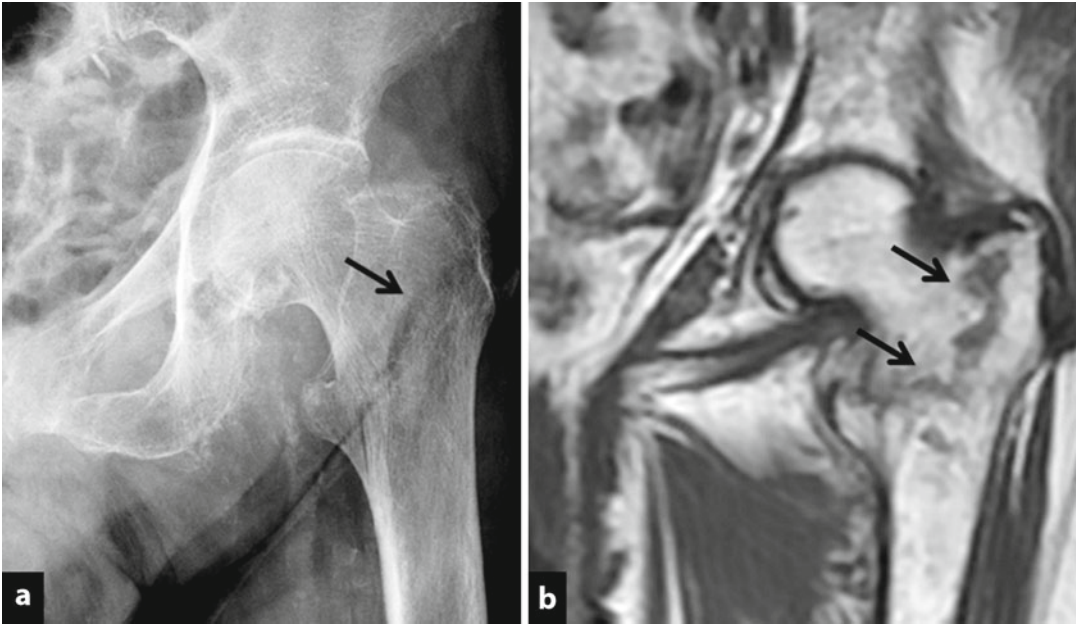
Femoral neck fracture. (a) Radiographs clearly show the fracture line (*black arrow*). (b) Coronal T1-weighted image shows the fracture as a hypointense line (*two black arrows*)
